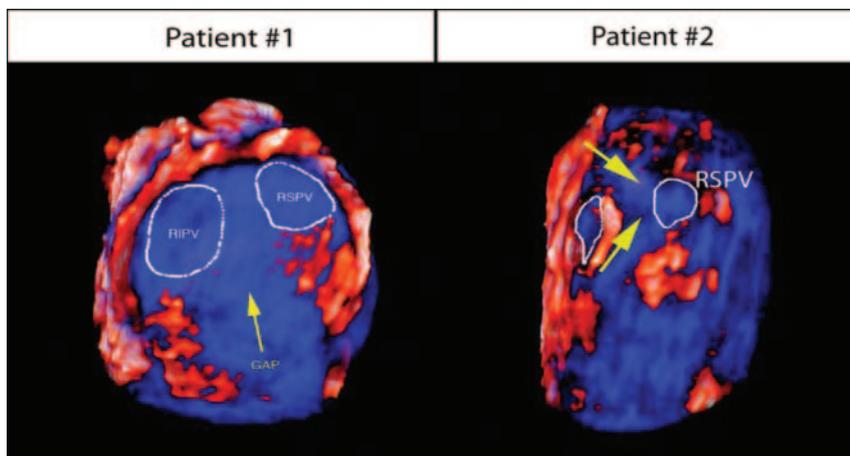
Identification of gap lesions after procedure failure. In our patient series, 5 patients had recurrence of AF after the second procedure. All patients had significant gap lesions on their follow-up MRI. Below is an example of 2 patients who had significant gap lesions (blue tissue, marked by yellow arrow) on their right PVs.
